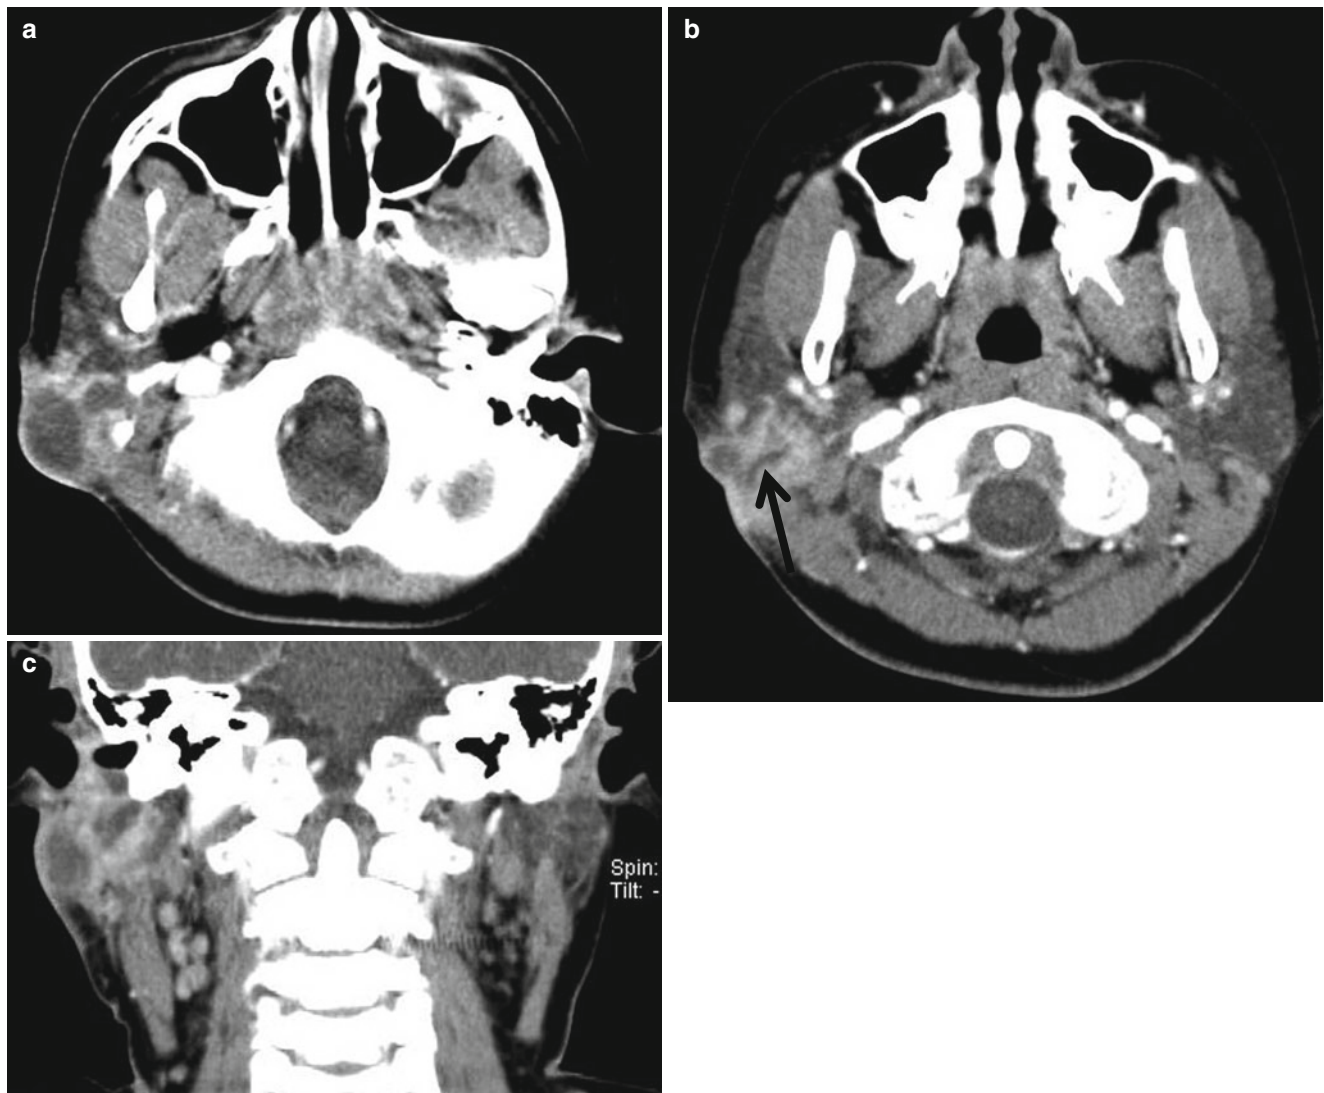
First branchial cleft cyst in an 11-year-old girl. (a, b) Axial CT scans show a complicated, thick-walled cystic mass in the right infra-auricular soft tissue layer with a fine sinus tract (*arrow*). (c) Coronal reformatted CT scan shows the cystic mass extending just below the ear
